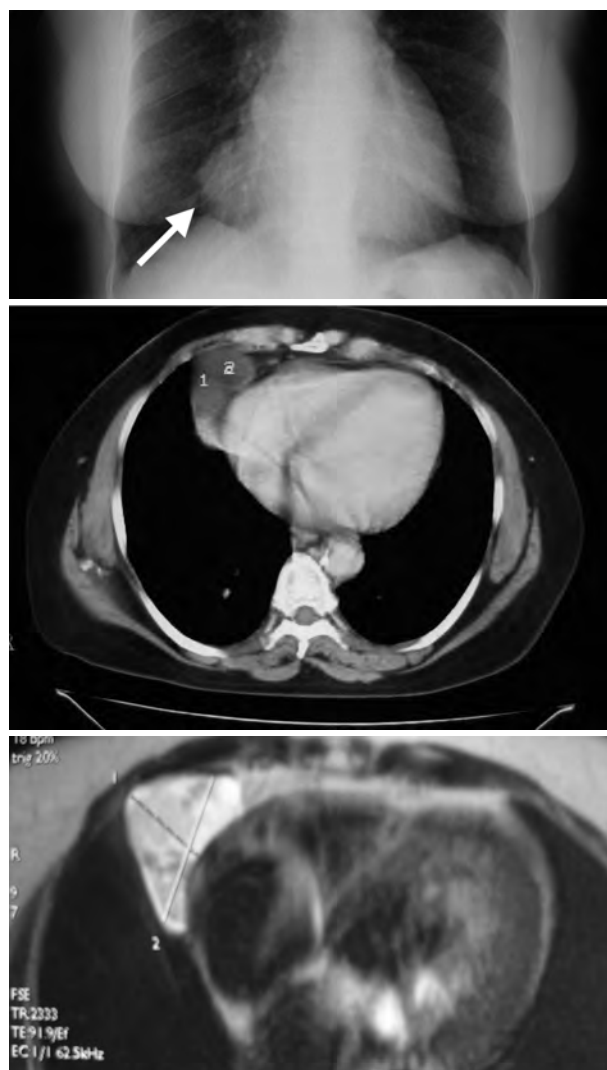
Anteroposterior chest X-ray (top), showing a homogeneous oval image of water density at the right cardiophrenic angle (arrow). Chest CT (middle) showing an elliptical mass of water density. Cardiac MRI (bellow) showing a discrete lobulated cystic mass measuring 33 x 52 x 30 mm, hypointense in weighted sequences at T1 and hyperintense at T2, without contrast capture, with a broad base of contact with the right atrioventricular parietal pericardium which does not produce mechanical compression of the heart.
